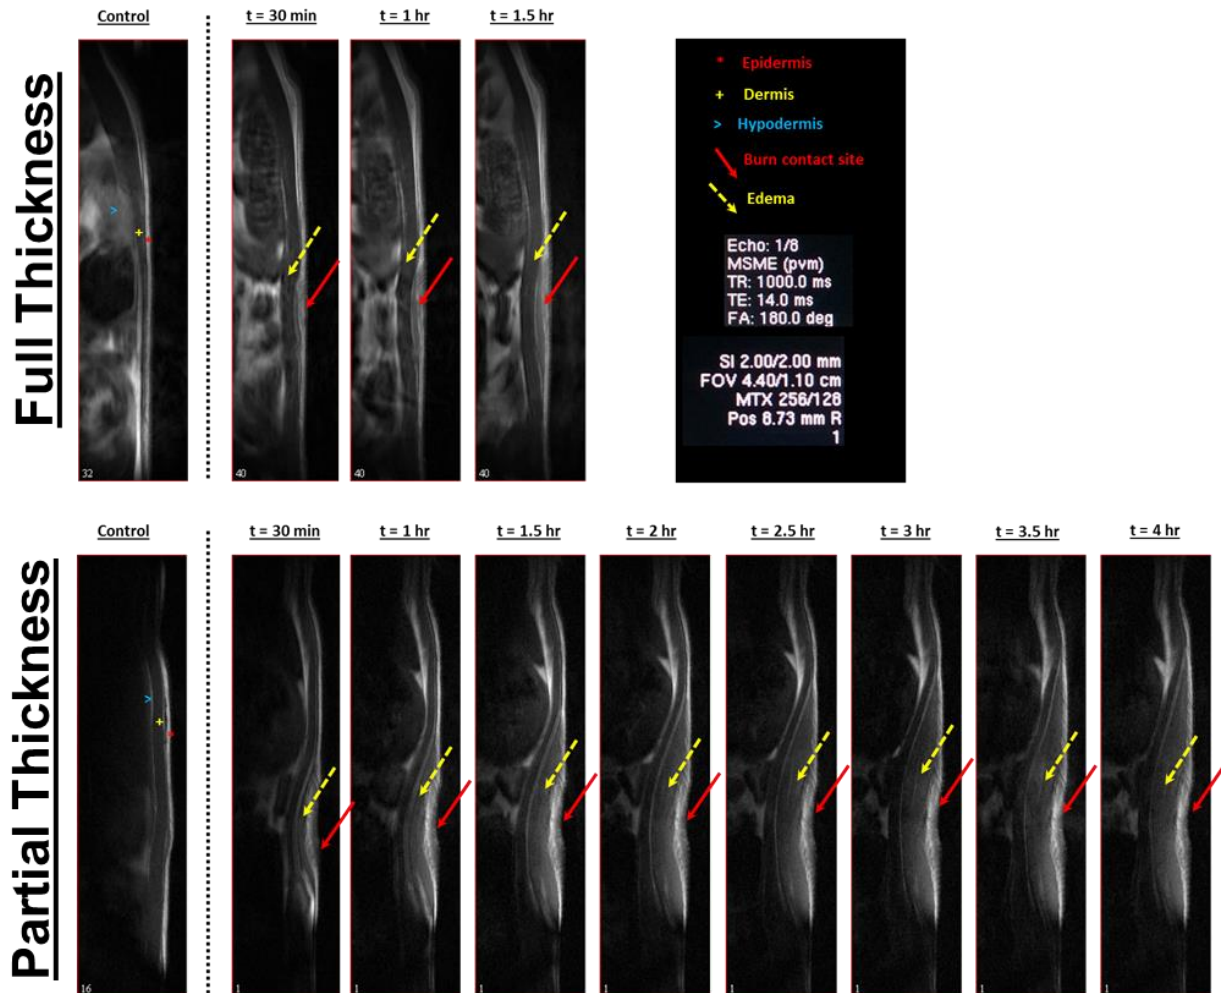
Continuous MRI scanning of a partial thickness and full thickness burn. In the control image, prior to burn induction, the red *, yellow +, and blue > indicate the location of the epidermis, dermis, and hypodermis, respectively. The solid arrow and dotted yellow arrow denote the spatial location of the burn contact area and the formation of edema, respectively.
